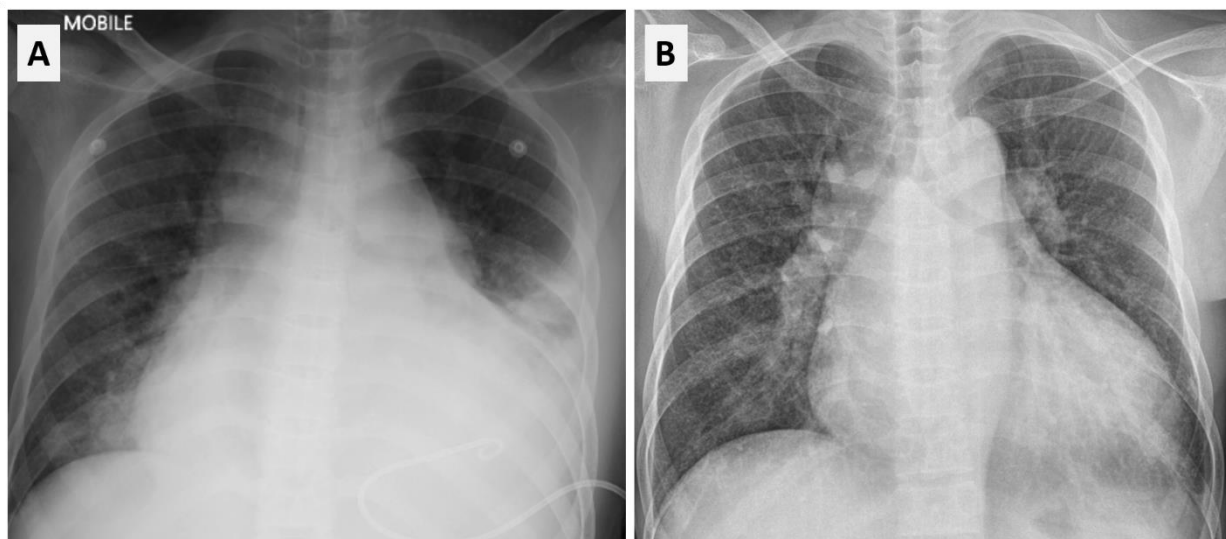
Panel A shows the post-pericardiocentesis chest radiograph which demonstrated a new left pleural effusion. Panel B shows follow-up chest radiograph showing no recurrence of pleural effusion.
